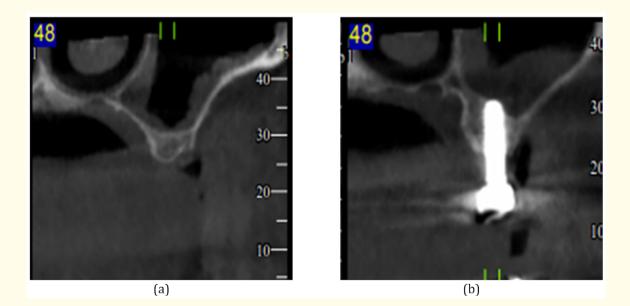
(a) CBCT Scan pre-operation with minimum residual bone height (1 mm) and excessive inflammatory thickness of the Schneiderian membrane due to root remnant, (b) Same position CBCT scan 4 months post-operation implant placement. Noticeable bone regeneration (8-9 mm) without any more sinus membrane pathology.
